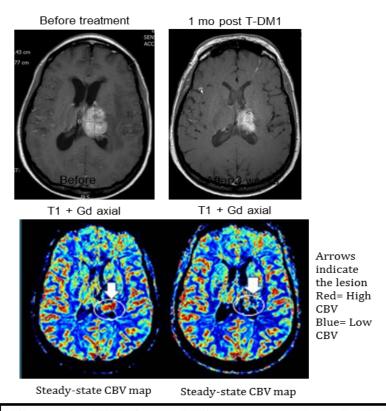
rCBV to evaluate response in a brain metastasis. A 38 year old woman with HER2overexpressing, node-positive breast cancer was found to have an asymptomatic left frontal brain metastasis during screening central nervous system imaging. The patient received multiple treatments, including stereotactic radiosurgery, systemic therapy with lapatinib and docetaxel, whole brain radiation therapy at 3000cGy, and IV trastuzumab and lapatinib, followed by recurrence each Subsequent neuroimaging with ferumoxytol (feMRI) showed increased relative cerebral blood volume (rCBV) along the superior and posterior margin of the thalamic lesion, indicative of active tumor. The patient was then started on trastuzumab-emtansine (T-DM1) an antibody drug conjugate. Three weeks later, there was a marked decrease in rCBV on steady-state feMRI and a partial response with 50% decrease of the enhancing area on MRI.
